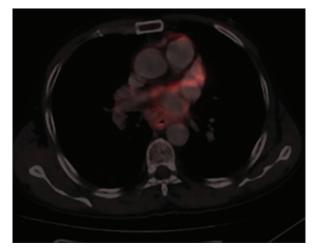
Positron emission tomography-computed tomography: Flourodeoxyglucose avid esophageal wall thickening (SUV_{max} 2.3)
